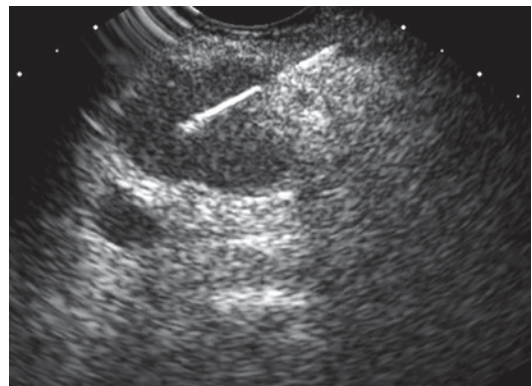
EUS-FNA of lymph node in the patient. EUS endoscopic ultrasound; FNA fine needle aspiration
